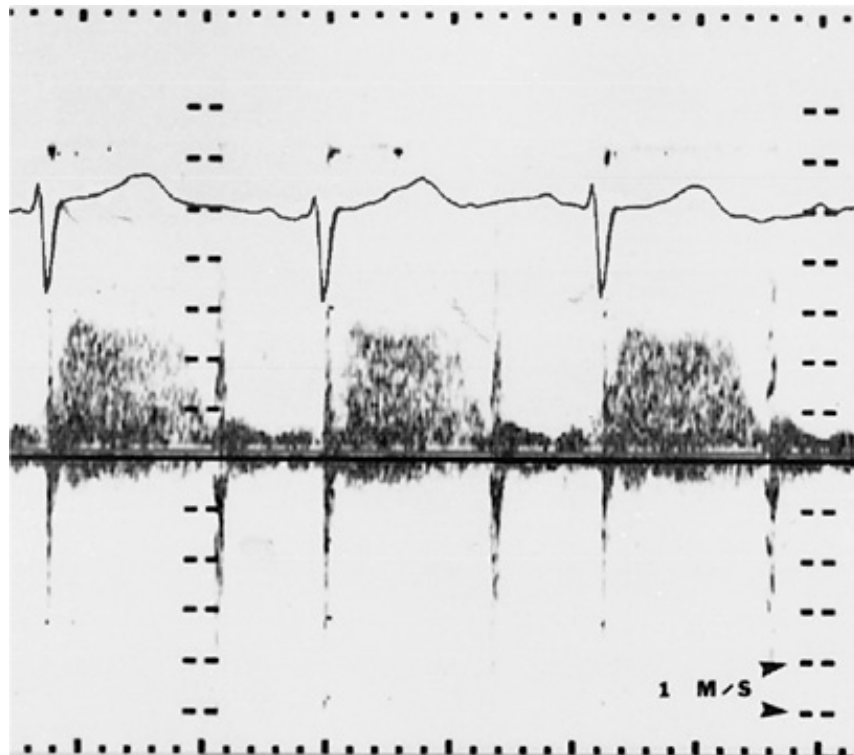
Continuous-wave Doppler with spectral display from the left lower sternal border of a child with a ventricular septal defect that demonstrates holosystolic turbulence with peak velocity = 2.8 m/s across the defect, compatible with an instantaneous systolic pressure difference of 31 mmHg between the right and left ventricles.
